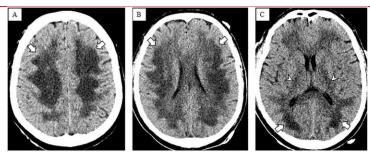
Non-contrast head CT. Axial CT images of the head at the level of the centrum semiovale (A), corona radiata (B), and basal ganglia (C) demonstrate diffuse confluent hypodensities in the supratentorial periventricular, deep and subcortical white matter (arrows) extending into the internal capsules (arrowheads).
